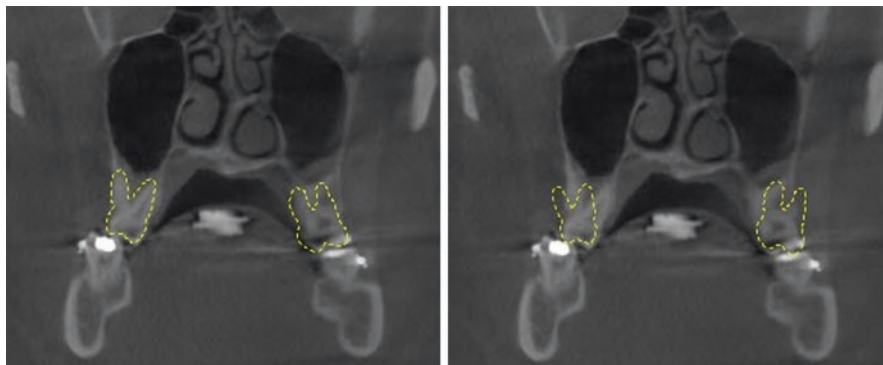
Transverse maxillary deficiency malocclusion. Note the decompensation efforts needed to optimize conditions to prepare for the skeletal surgery required to manage this disharmony. Severe adverse changes to the periodontium are likely to result in the buccal alveolar bone complex with decompensation movements planned. Reprinted with permission from Mandelaris GA, Neiva R, Chambrone L. American Academy of Periodontology Best Evidence Consensus on Cone Beam Computed Tomography and Interdisciplinary Dentofacial Therapy. A Systematic Review Focusing On Risk Assessment of the Dentoalveolar Bone Changes Influenced By Tooth Movement. *J Periodontol* 2017; 88(10): 960–977
